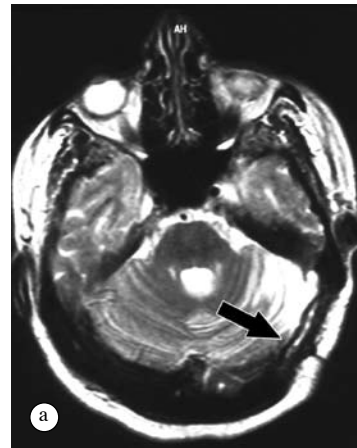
A postoperative a) contrast-enhanced cranial MRI and b) CT shows that the mass was totally excised.
